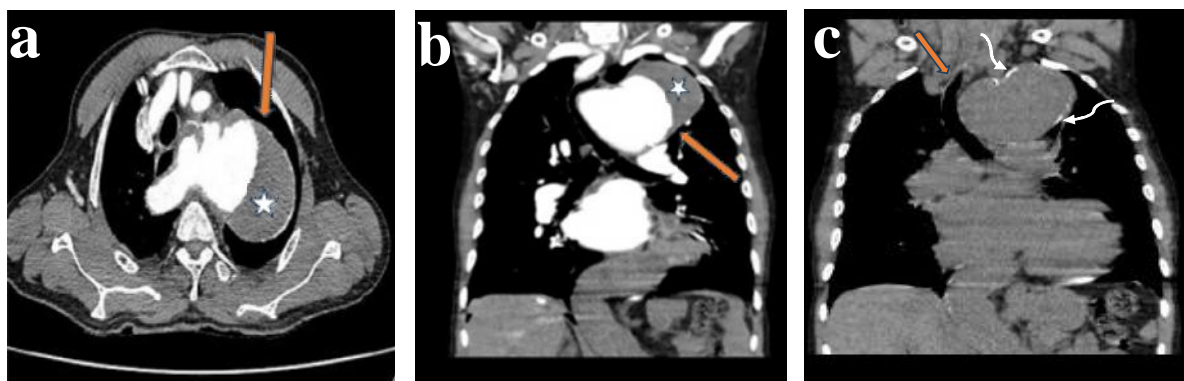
Axial contrast enhanced chest CT (a) and coronal reformat (b) showing the large TAA (arrow) with intramural thrombus (*). The non-enhanced coronal reformat (c) shows mass effect on the trachea (arrow) and atherosclerotic plaques on the aneurysmal wall (curved white arrows).
